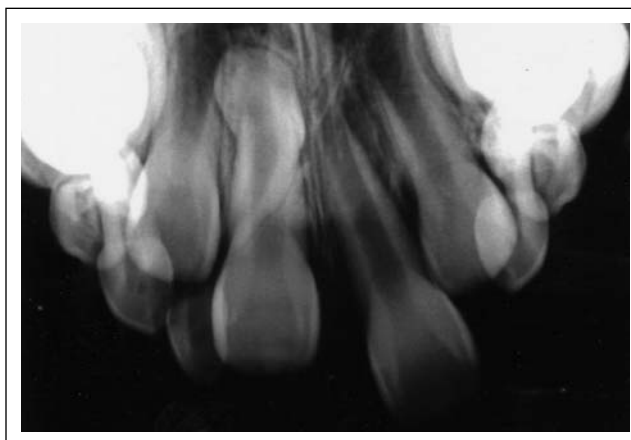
Radiographic view shows that the maxillary left lateral incisor is extruded and the impacted supernumerary tooth is interfering with the eruption of the neighboring right central incisor.
